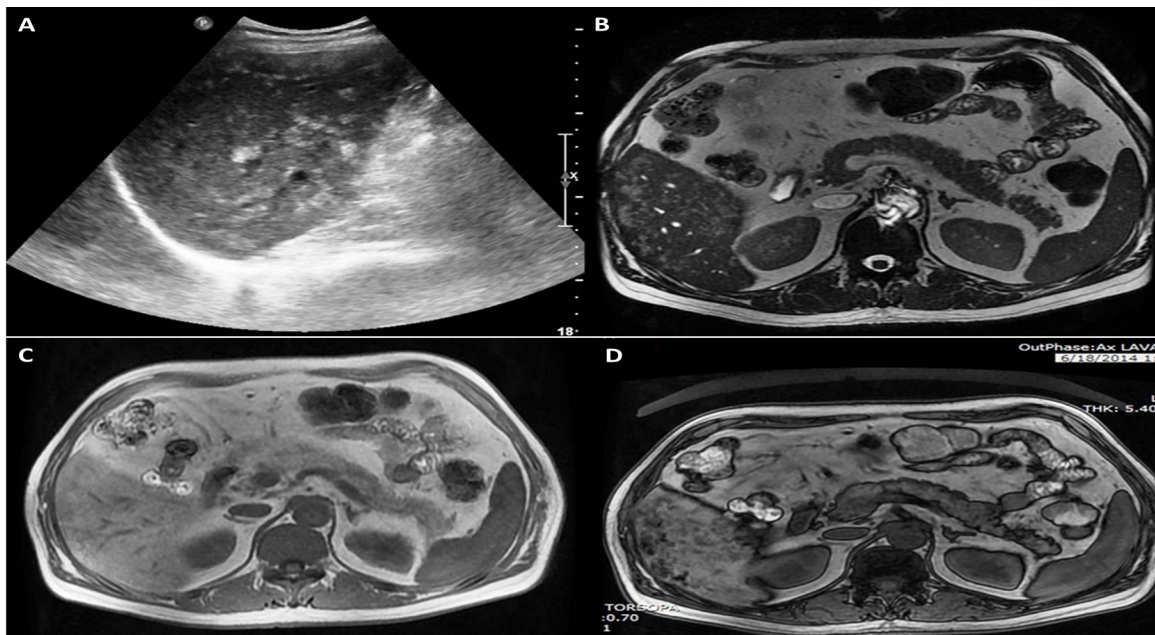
Ultrasound image (A) and corresponding MRI Axial Fiesta imaging (B) showing multiple small ill-defined hyperechoic areas and corresponding patchy hyperintense areas respectively; magnetic resonance imaging in-phase (C) with the corresponding opposed-phase (D) acquisitions showing signal loss in patchy areas corresponding with multifocal patchy fatty infiltration.
